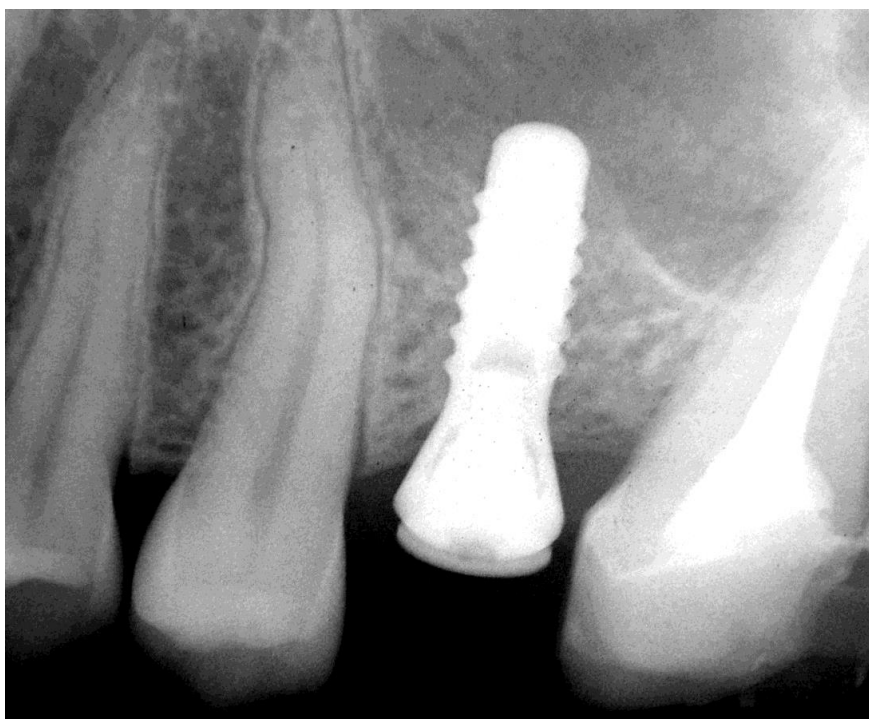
X-ray 8 months after surgery.*
